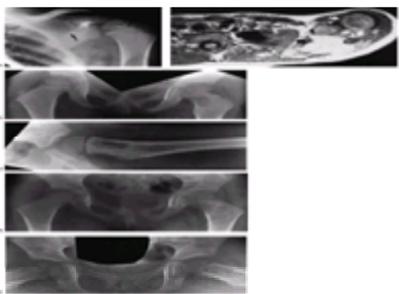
A 2-year, 6-month-old girl who presented with swelling in the posterior region of the scapula. A: Anteroposterior view of the scapula demonstrates a lytic lesion (arrow). Biopsy showed Langerhans cell histiocytosis. B: Four months later, the patient developed recurrent swelling and drainage from the left scapular biopsy site. Magnetic resonance image before the second biopsy of the scapula shows increased signal intensity with spread into soft tissues anterior and posterior to the scapula. White arrow points to the humeral head and spinal cord. Black arrow points to the mass invading the scapula. Repeat biopsy also demonstrated Langerhans cell histiocytosis. The scapular lesion subsequently resolved without problems. C: Anteroposterior radiograph of the pelvis at age 3 years, 4 months. At that time, the patient had developed a limp and pain in the left leg. Radiographs show a lytic lesion in the proximal femur. Spica cast immobilization was used for 7 weeks. D: Frog-leg lateral radiograph of the left hip at age 3 years, 4 months. E: Anteroposterior radiograph of the pelvis at age 3 years, 6 months. F: Frog-leg lateral radiograph of the pelvis at age 3 years, 6 months. Trabecular pattern indicates progressive healing of the Langerhans cell histiocytosis. (Courtesy of Gary D. Bos, M.D.)
